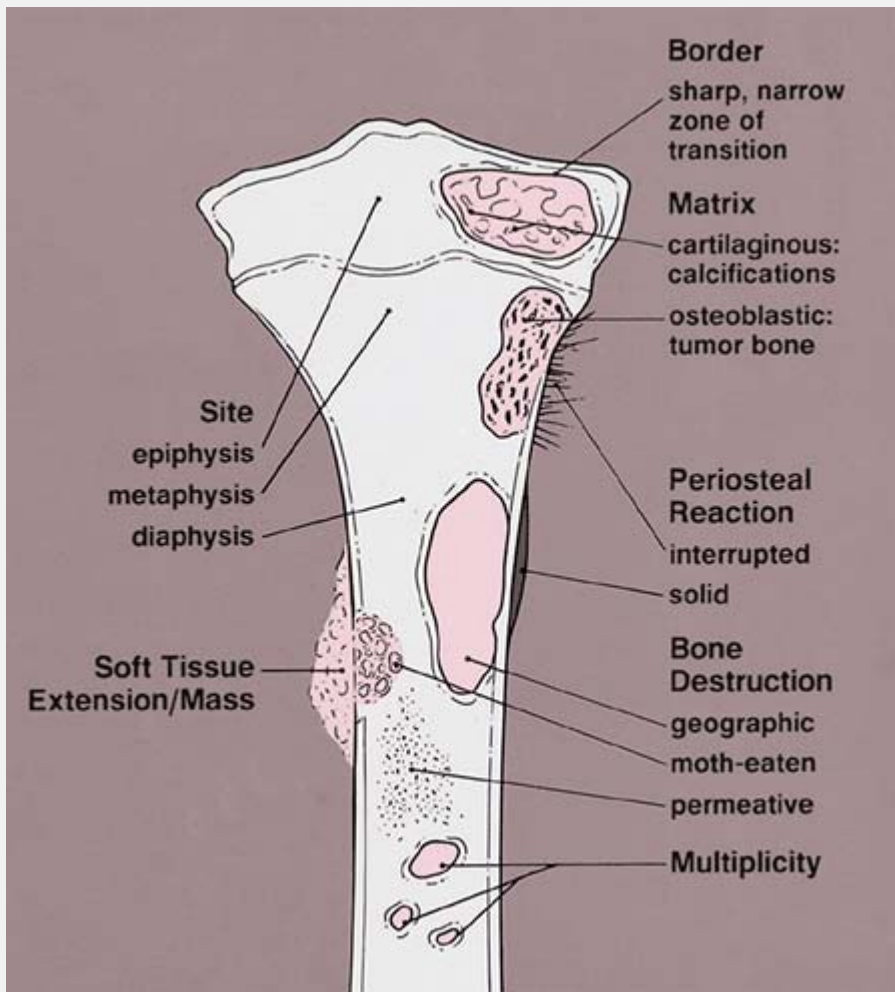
Radiographic features of tumors and tumor-like lesions of bone.
